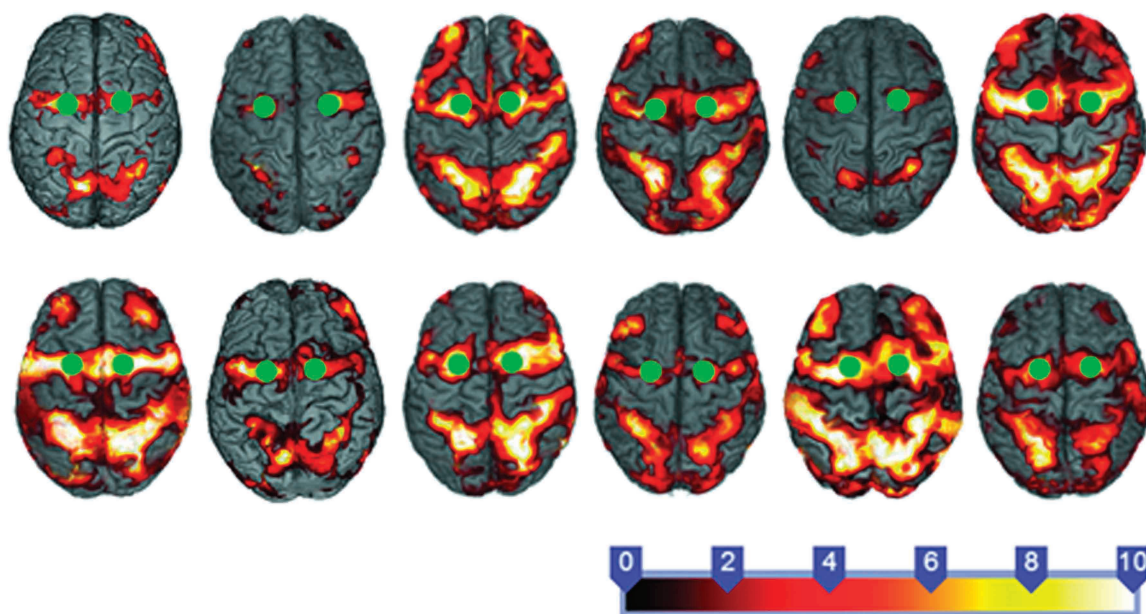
The activation maps for all 12 participants. For this figure, the MRI scans and activation maps were normalized to Montreal Neurological Institute space. In all participants, the FEFs are clearly activated.
